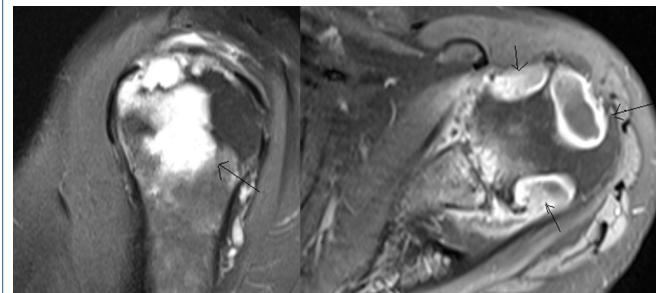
Hyperintense loculated areas seen in T2 cross-sections in the axial and coronal MRI imaging prior to the operation.
